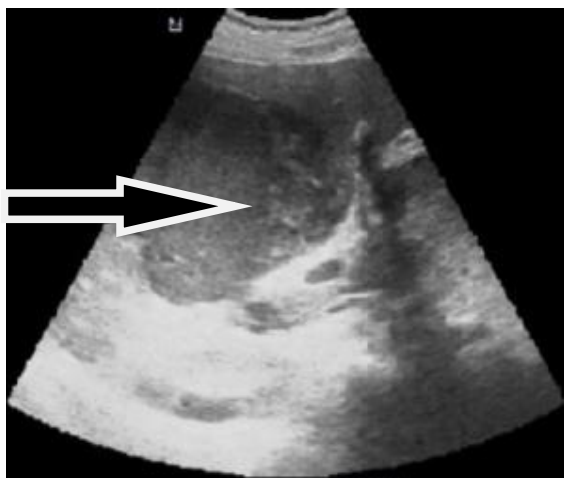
Ultrasound liver abscess.
